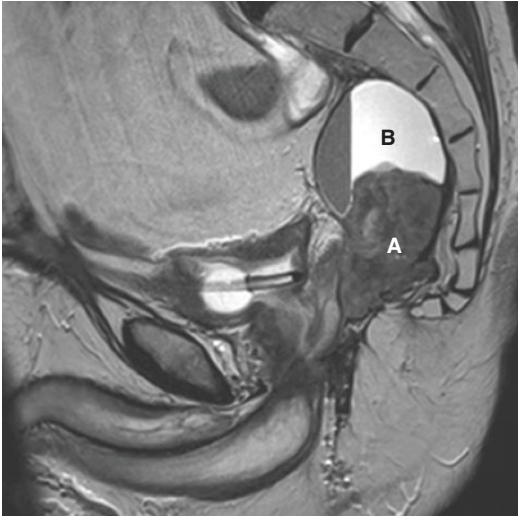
MRI demonstrating central recurrence (A) at rectal stump following previous Hartmann's procedure with associated cystic cavity (B)
